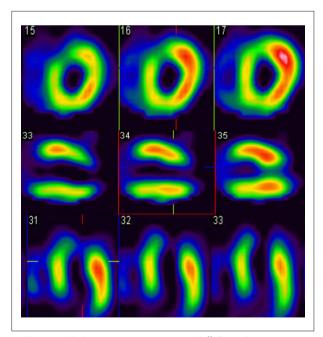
Perfusion scintigraphic imaging with ^{99m}Tc-tetrofosmin acquired during an episode of chest pain. A large area of reduced perfusion is seen in the interventricular septum, anterior wall, apex and inferior wall of the left ventricle. Coronariography showed important lesions in the anterior descending artery and in the right coronary artery.
